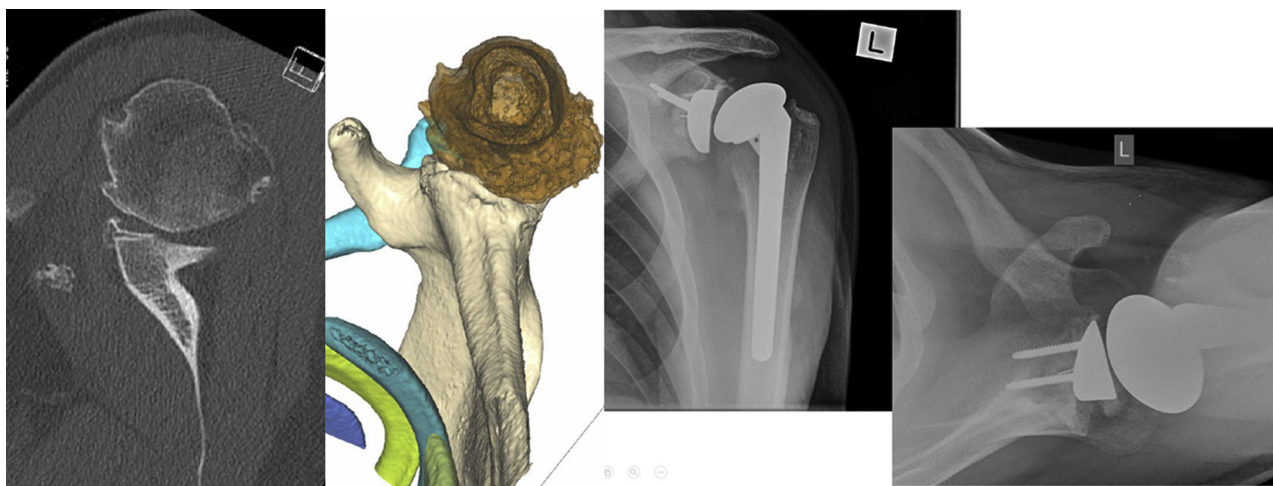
Clinical case example correction. A 46-year-old male with 3 years of severe pain and loss of motion. Preoperative 2D computed tomography (CT) scan and 3D modeling (VPOPS; True Life Anatomy) identified that a 30° PMGA augment would best correct retroversion, and this was confirmed on postoperative plain axillary radiograph. Patient required bilateral anatomic total shoulder arthroplasty.
